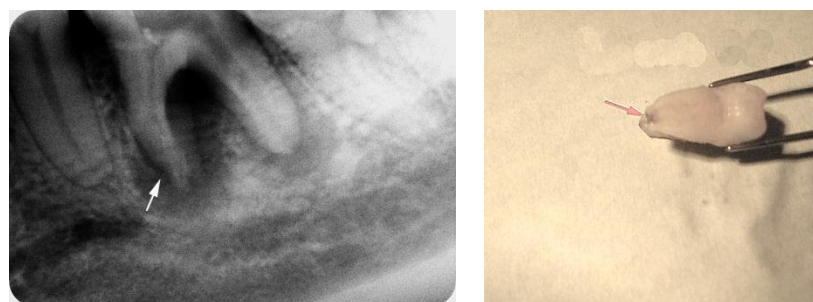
a – Radiographic aspect (3.6.); b. Macroscopic aspect (3.6.)
